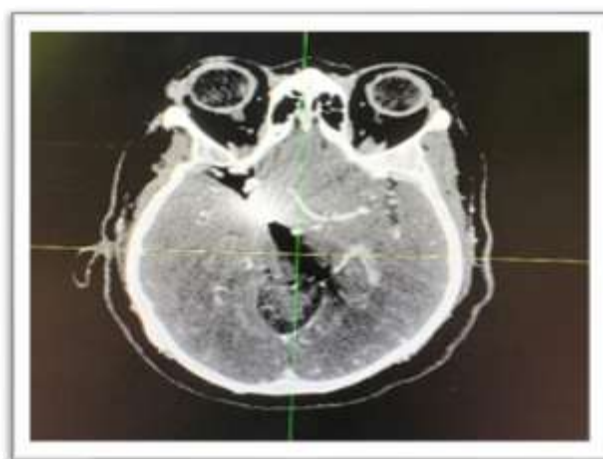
CT Image-Axial View
